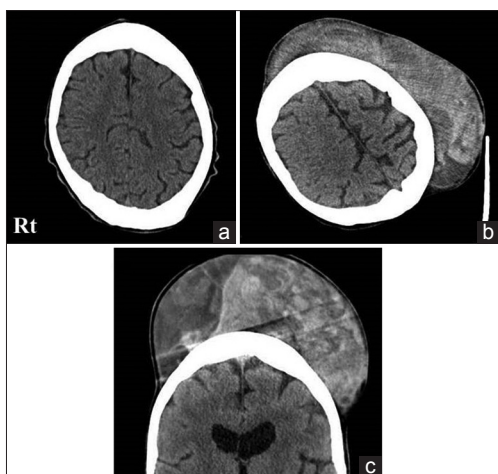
(a) Computed tomography (CT) scan taken up on admission showing a small subcutaneous hemorrhage. (b) Axial CT scan taken 2 h after the first CT scan. (c) Coronal CT scan taken on the same time as (b)
